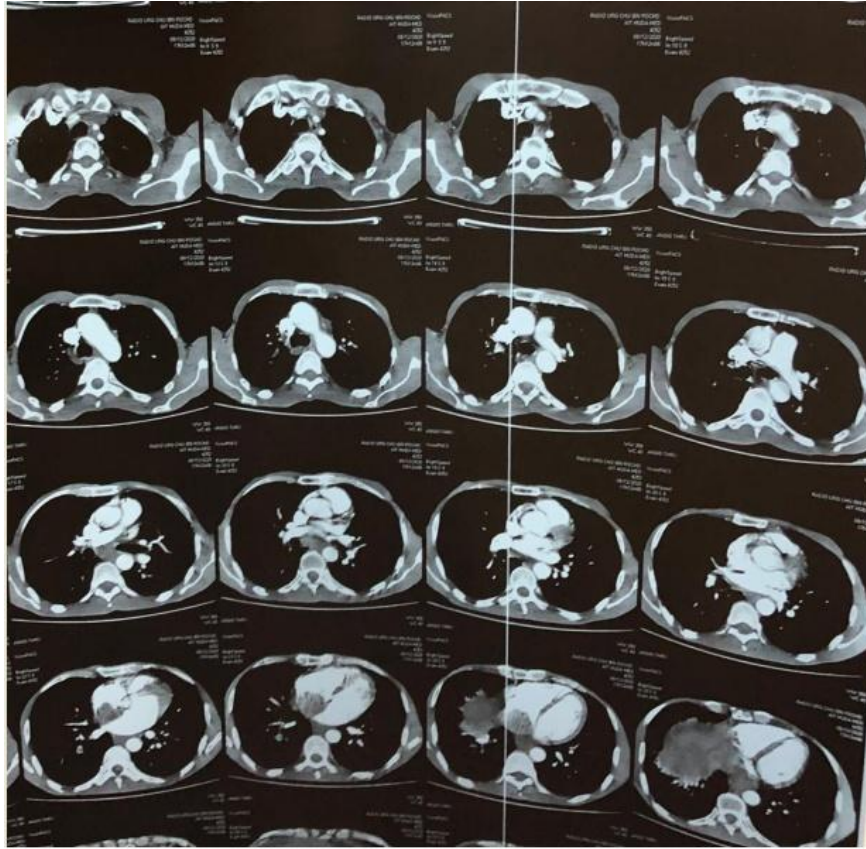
Chest and abdominal Contrast-enhanced CT scan showing a right lower lobe and upper segmental pulmonary embolism, with a thrombus tumor extended from the IVC to the RA.
